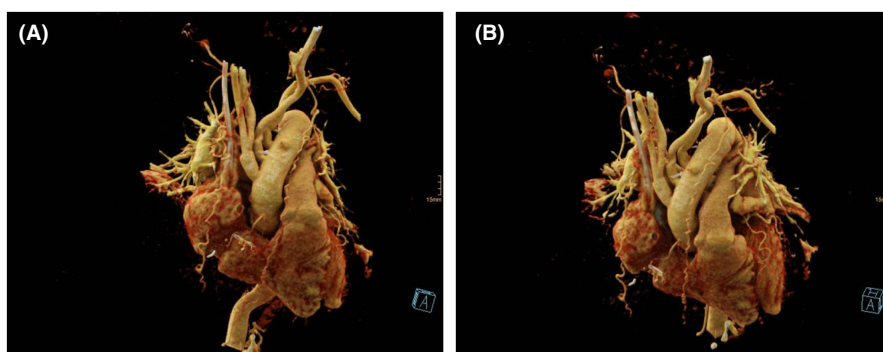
Postoperative 3D-CT reconstruction of the aorta
